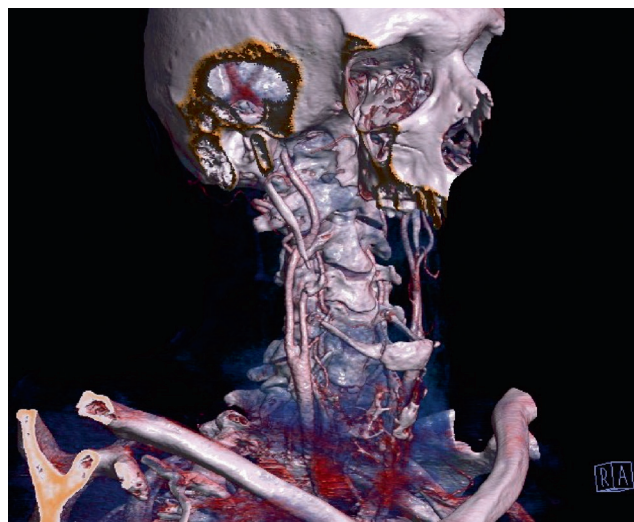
3D reconstruction of CT angiography showing conflict of elongated styloid process and internal carotid artery on the right side.
